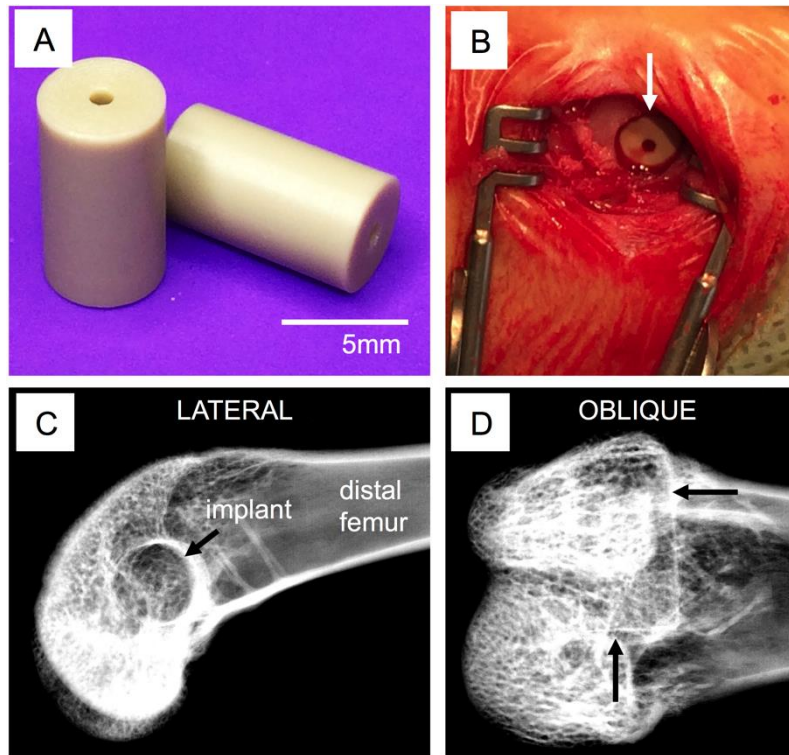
Implantation. Size and surface finish of PEEK implants (A). Surgical site with implant inserted (B) and x-ray visualization of placement location—arrows indicate the defect boundaries within which the implant is located (C-D).
